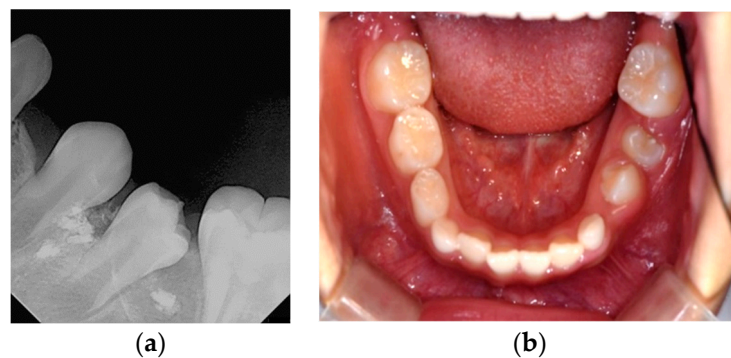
Six months after marsupialization: (a) periapical radiograph; (b) intraoral photo. Left mandibular premolars have erupted and extruded canal filling materials still exist.
